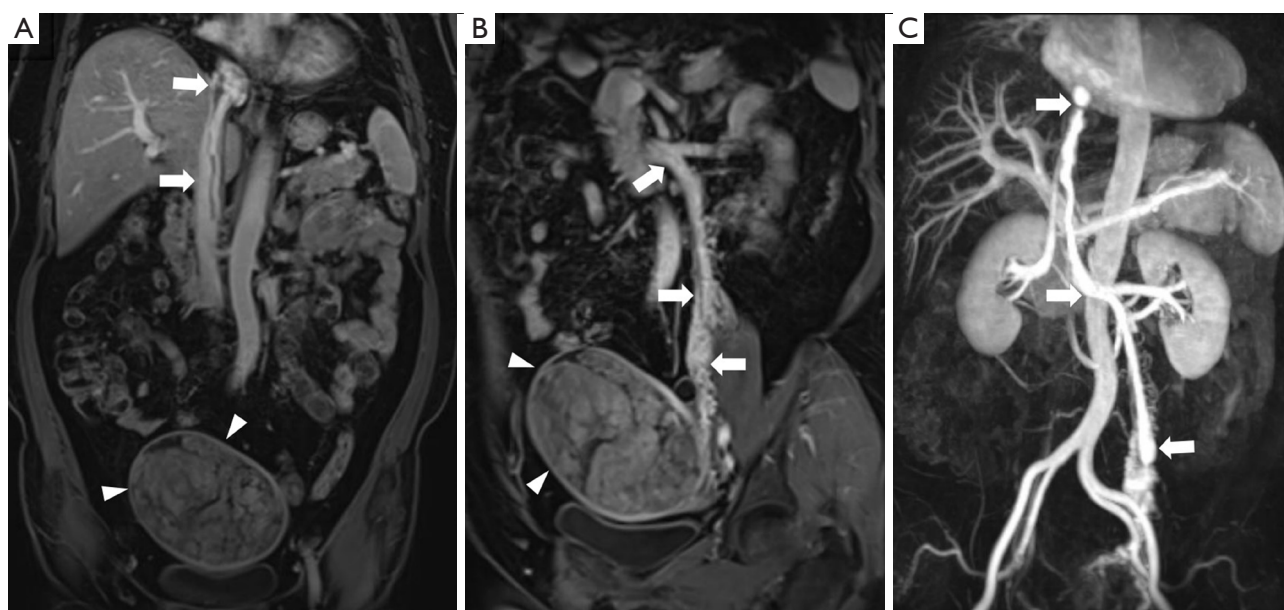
Gadolinium-enhanced magnetic resonance imaging scans. The enhancement of the cord-like mass was more discernible on the magnetic resonance images than the computed tomography scans due to the superior soft tissue contrast (arrows), and linear filling defects were also prominently visible. An inhomogeneously enhanced, enlarged soft tissue mass was identified on the anterior wall of the uterus (triangles). (A) Coronal reconstruction. (B) Oblique-sagittal reconstruction. (C) Maximum intensity projection in magnetic resonance angiography.
